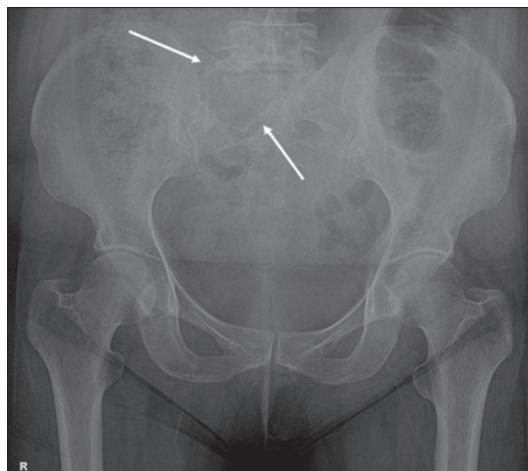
Frontal radiograph of pelvis reveals a large expansile lytic lesion involving the right sacral ala (arrows).
